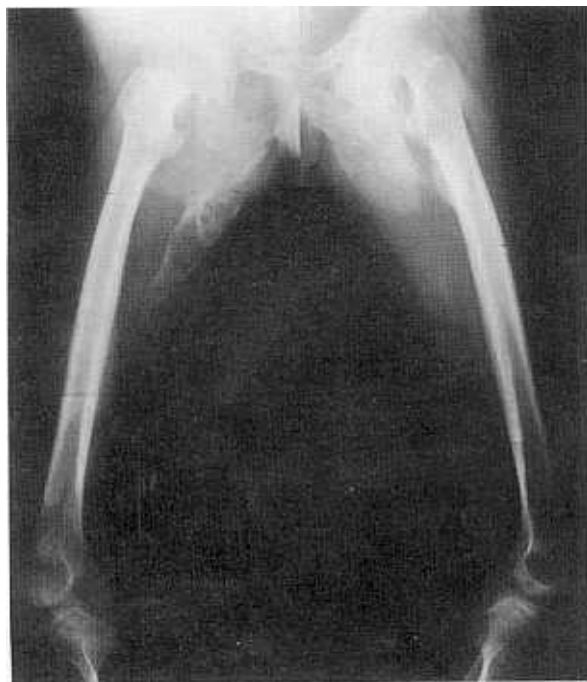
Plain X-ray revealed HO at both hip joint areas, the entire right thigh and the left upper thigh.
